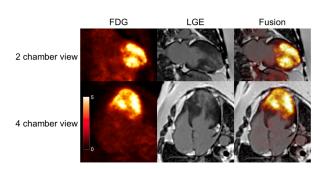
¹⁸F-fluorodeoxyglucose PET/MRI images of 2- and 4-chamber views. Intense ¹⁸F-fluorodeoxyglucose (FDG) uptake was observed on the middle walls in the left ventricular myocardium. Late gadolinium enhancement (LGE) was detected on the apex. Fusion images clearly showed the markedly increased FDG uptake in hypertrophied myocardial regions.
